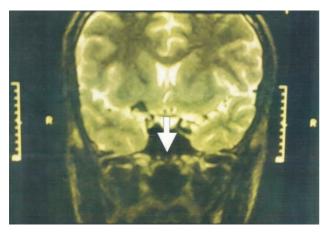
MRI of brain with gadolinium showing atrophic pituitary gland.
